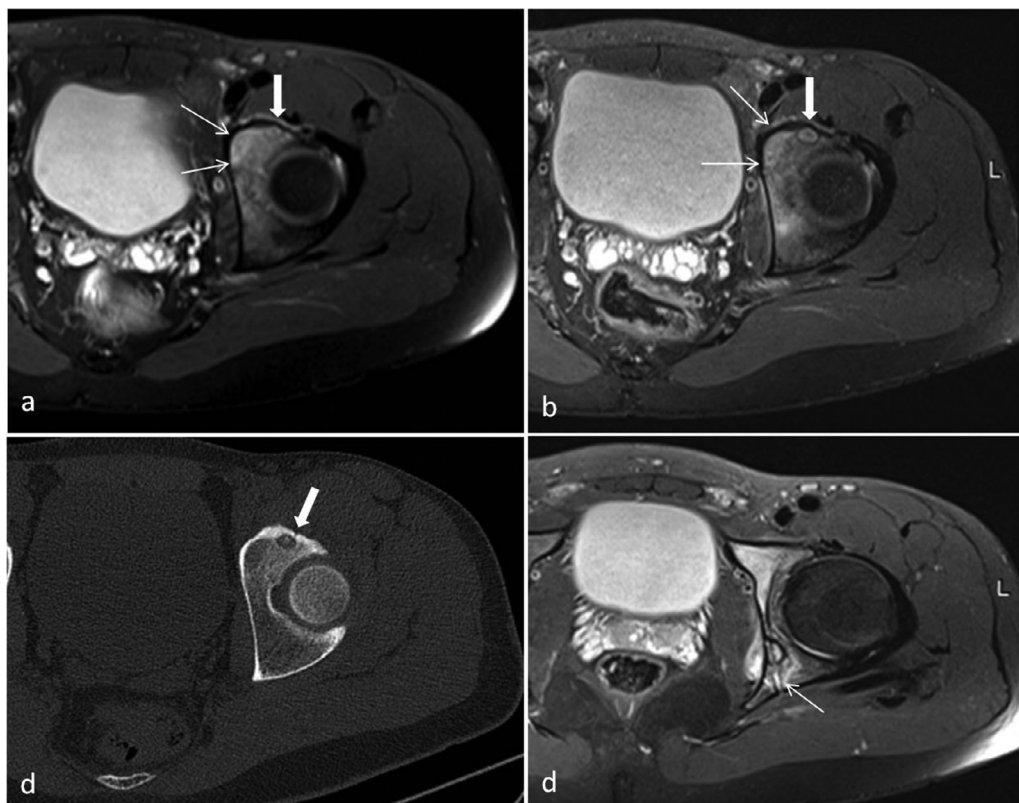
(a) Pretreatment MRI. Nidus in the anterior acetabulum (thick arrow) is obscured by the edema (thin arrows). (b) In the postablation MRI scan the second nidus (thick arrow) can be easily identified. (c) CT image the same day and same level identifies the nidus with central mineralization even better. (d) Postablation needle tract as a consequence of the performed RFA procedure
